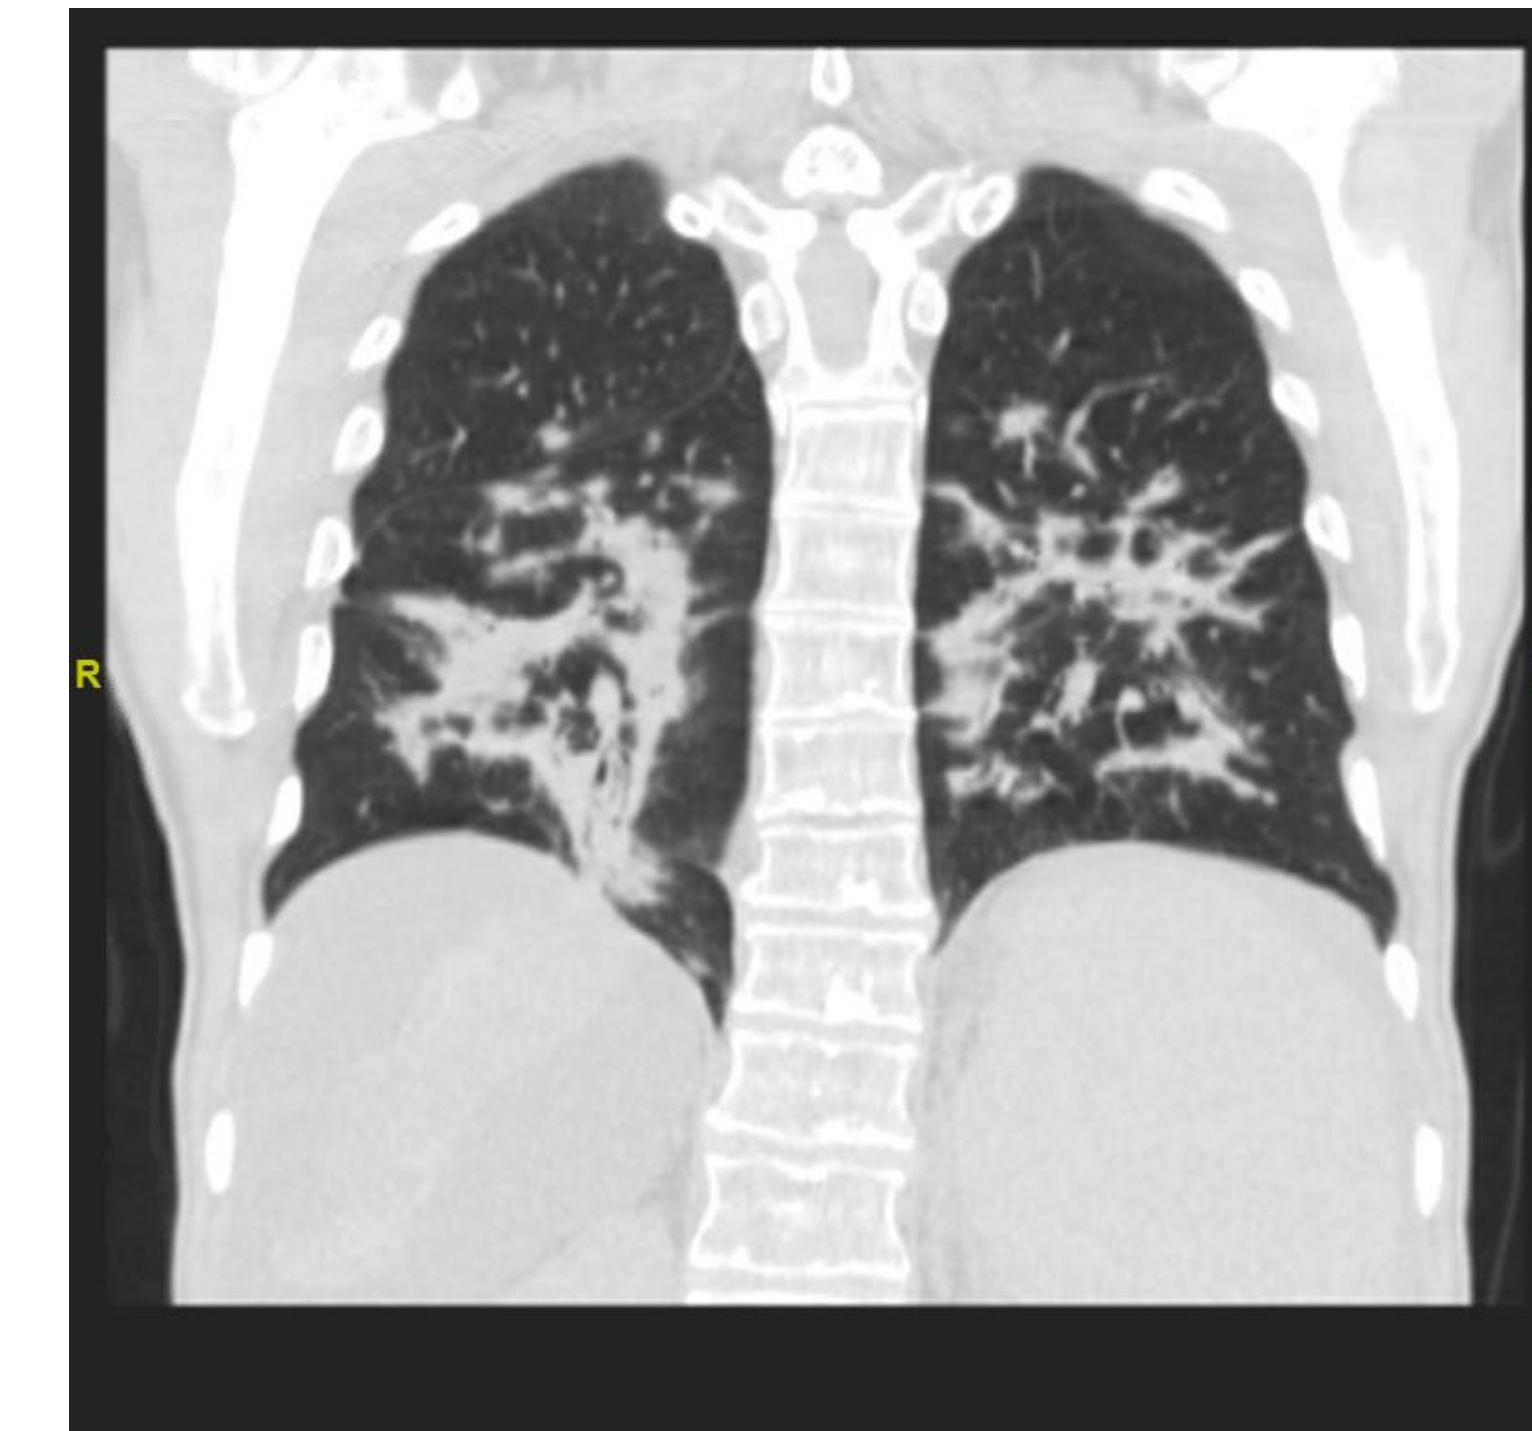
CT chest of case 2; 3 months after second treatment with Y-90
